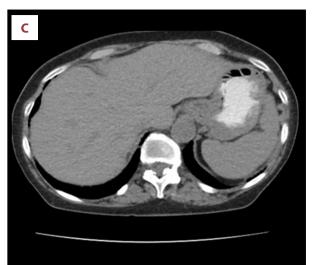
Axial computed tomography (CT) images and esophagogastroduodenoscopy (EGD) in a 72-yearold female. (A) Initial CT showed significant wall thickening at gastroesophageal junction (GEJ) with nodular abnormality projecting into the proximal stomach (white arrow) and multiple hypodensities of the liver. (B) EGD showed fungating mass at GEJ. (C) CT showed improving gastric cardia mucosal thickening and decrease in hepatic metastasis 6 months after initiation of chemotherapy.
